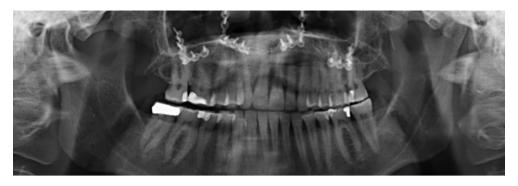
Postoperative panoramic radiograph depicting four osteosynthesis plates, which bridge the Le Fort I plane in typical manner
